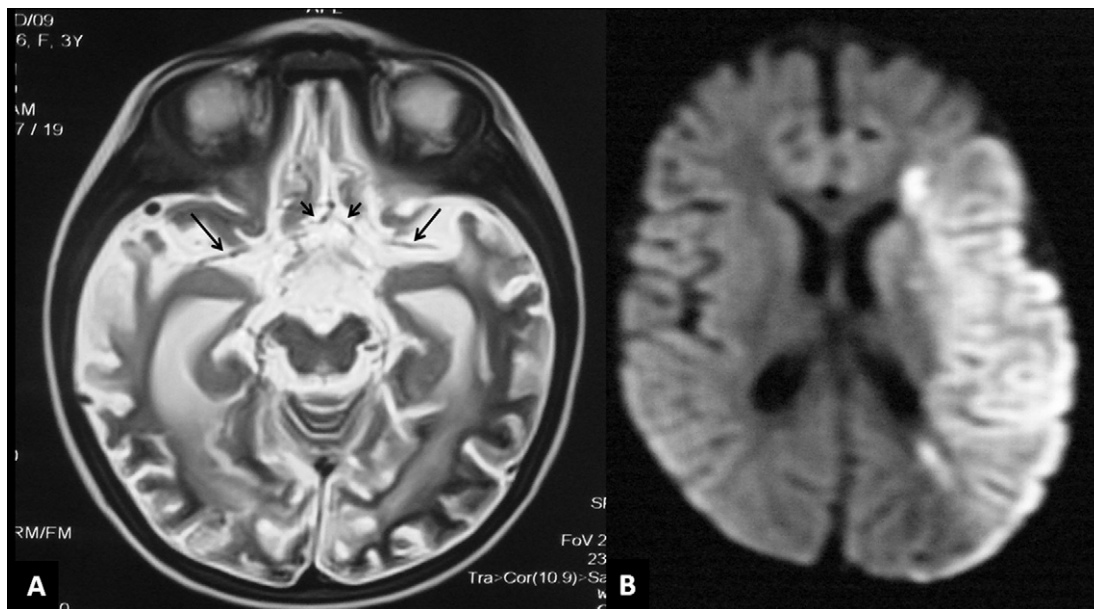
Brain MRI examination. (A) T2 weighted axial imaging shows bilateral diffuse cerebral atrophy. The vascular flow voids of bilateral middle cerebral arteries (long arrows) and anterior cerebral arteries are attenuated. (B) Diffusion weighted axial image at a higher level shows acute infarct in left middle cerebral artery territory.
